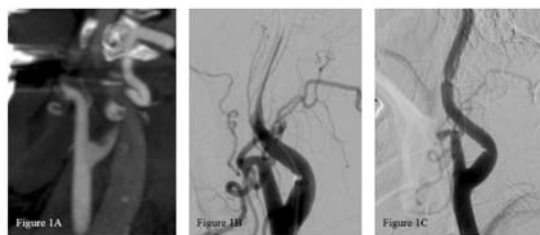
Example of cervical ICA pseudo-occlusion on CTA with a noncorresponding cause of apparent occlusion found on DSA. (A) Pseudo-occlusion of the left cervical ICA in a 69-year-old woman. CTA shows a sharp, flame shaped leading contrast edge at the level of the cervical ICA, with T-occlusion present. (B) DSA of this patient shows a slowly moving upward of contrast and finally a patent ICA (C) after mechanical thrombectomy for the distal ICA occlusion.
